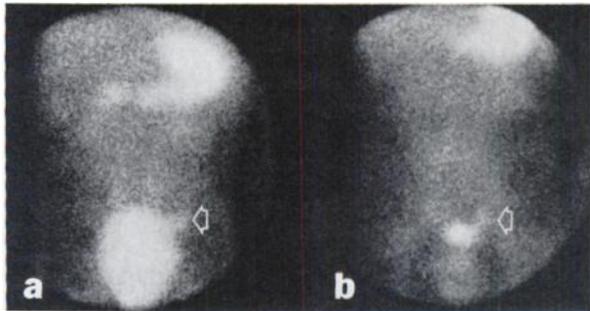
Positive scintigrams with focus of activity associated with the left upper margin of urinary bladder (a). Lesion follows bladder after voiding (b). Intravenous pyelogram and cystograms were normal; ectopic gastric mucosa was present in excised Meckel's diverticulum.
